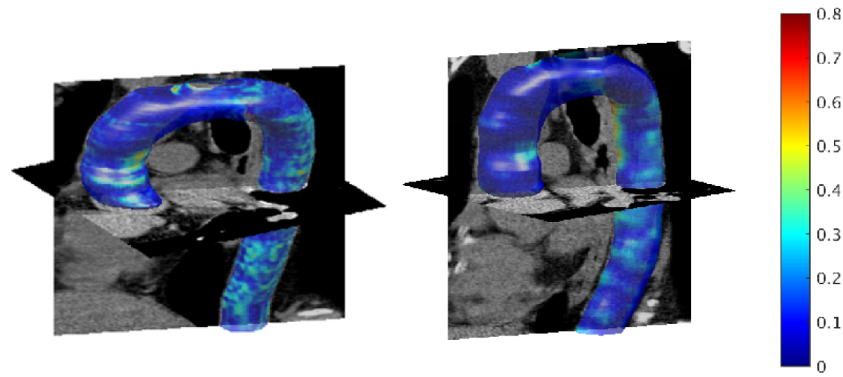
Segmented aorta in 3D for two sample CT scans. Colormap indicates the closest point Euclidean distance (in mm) between automatically segmented and manually labeled aorta surfaces.
